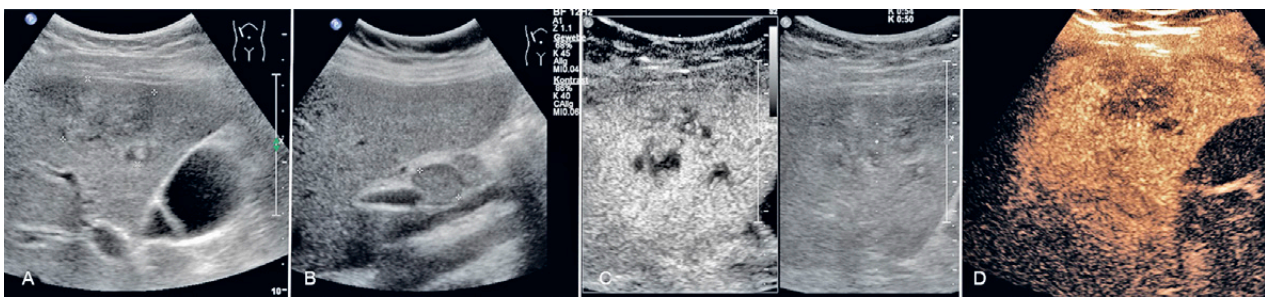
Fasciolosis hepatica (serological proven) in a 19-year-old woman with abdominal feeling of pressure and eosinophilia of 30%. The grey scale ultrasound displays confluent hypoechoic lesions up to 4 cm in the right liver lobe, which were blurred and without a halo (A). In the porta hepatis, enlarged and rounded lymph nodes up to 2.2 cm were detected (B) CEUS demonstrates arterial contrast enhancement in the outer areas (C) and increasing washout in the late phase (3:49 minutes, D).
